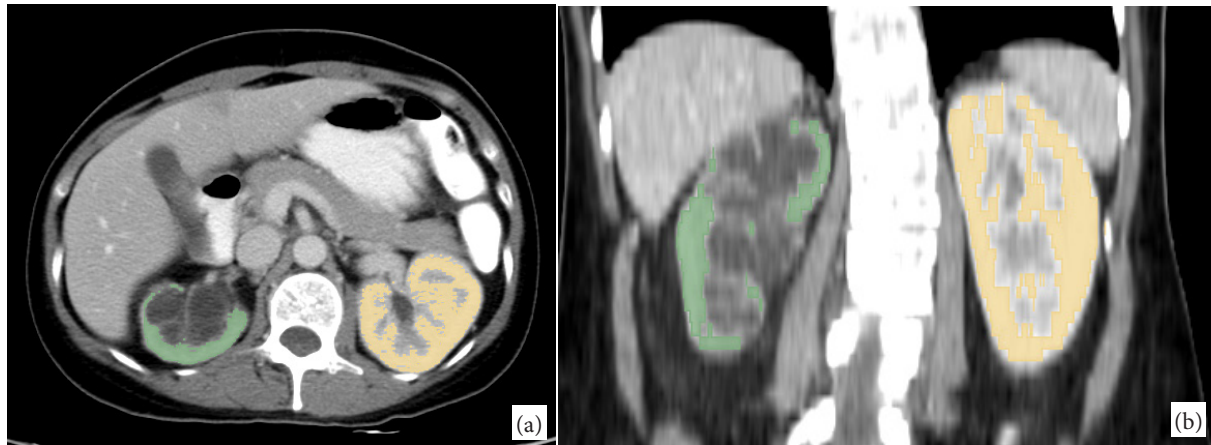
CT image in arterial phase. (a) A region of interest (ROI) was drawn around kidney cortex in every slice of axial image. (b) Coronal view of CT image reconstructed from axial image after ROI was drawn
